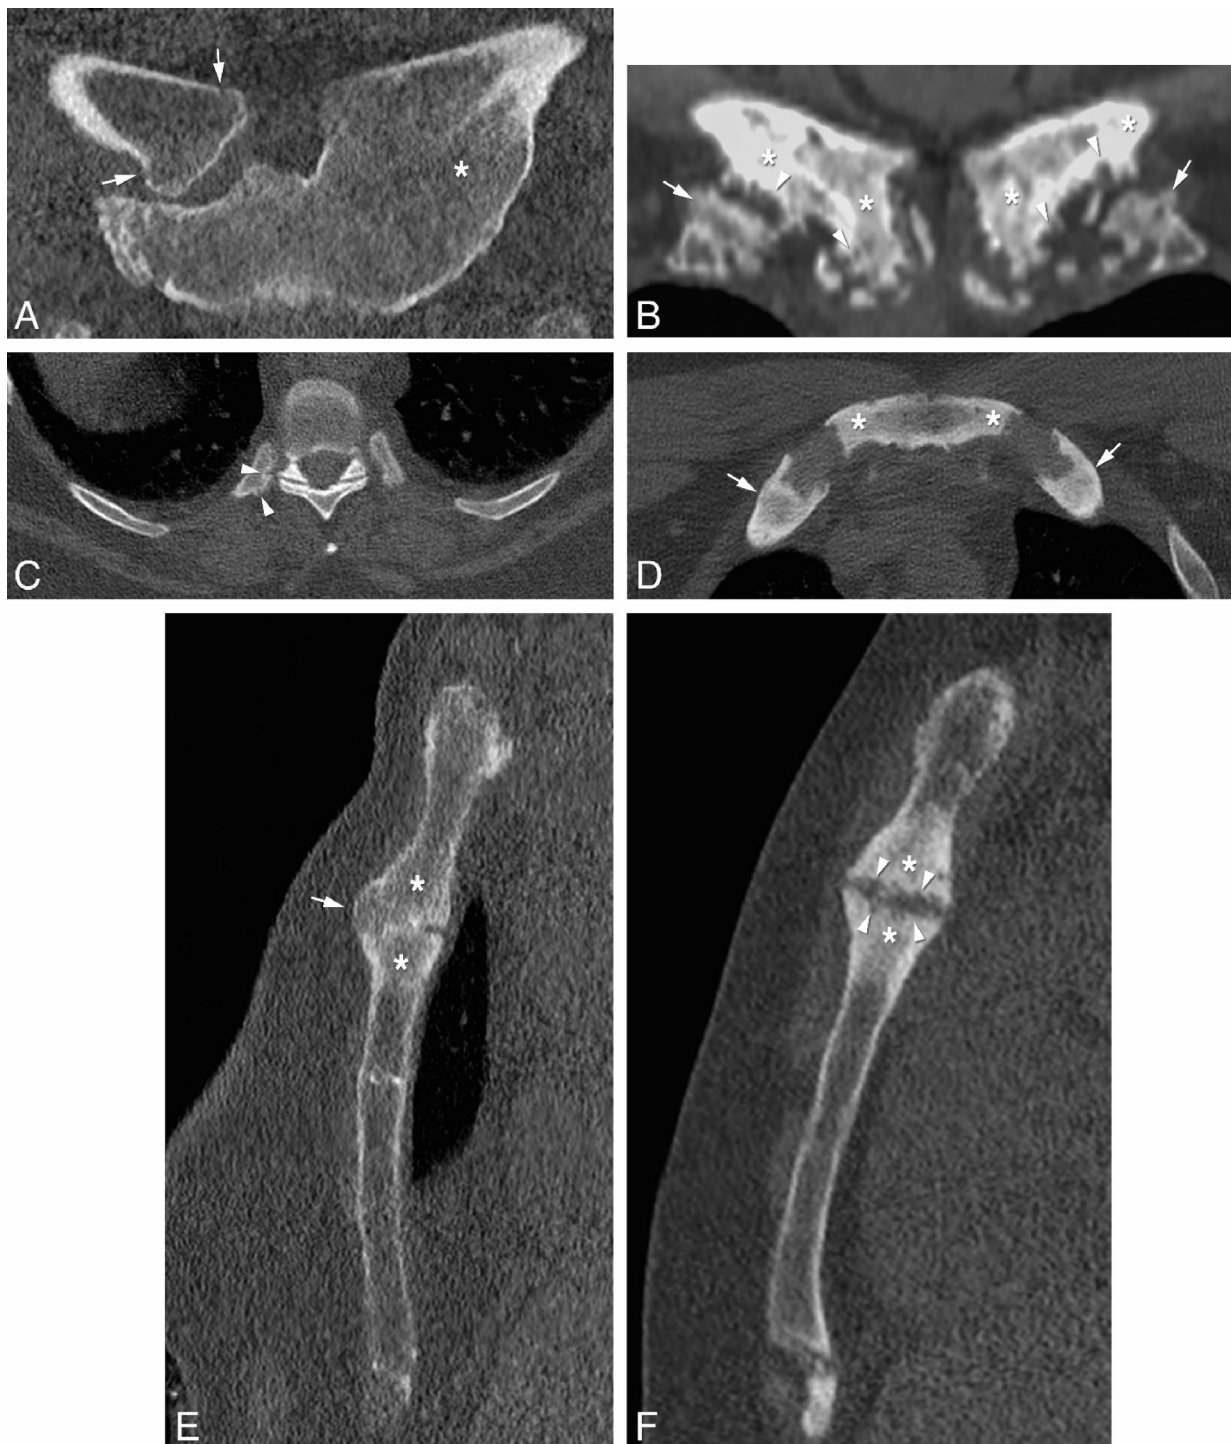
Cases of significant involvement of the ACW in adult CNO. A: (coronal CT view) hypertrophy and sclerosis of the right clavicle and of the sternum at the level of the sternoclavicular (SC) joint (arrows); on the left side, severe calcification with complete ankylosis and hyperostosis (asterisk). B: (coronal CT view) prominent bilateral sclerosis, hyperostosis (asterisks) and “kissing” erosive changes (arrowheads) of the proximal end of the clavicles, with moderate calcifications of the costoclavicular (CC) ligaments (arrows). C: (axial CT view) involvement of the costovertebral (CV) joint on the right side, with subtle erosive changes (arrowheads). This represents a less common but classical manifestation of CNO. D: (axial CT view) important sclerosis and hyperostosis of the anterior costal arches on both sides, at the level of the costochondral (CC) junctions (arrows), with associated involvement of the sternocostal (SCo) joints (asterisks). E: (sagittal CT view) important sclerosis and hyperostosis in the manubrium and corpus sterni (asterisks), with partial ankylosis of the joint on the anterior side (arrow). F: (sagittal CT view) significant sclerosis and hyperostosis in the manubrium and corpus of the sternum (asterisks), together with erosive changes (arrowheads).
